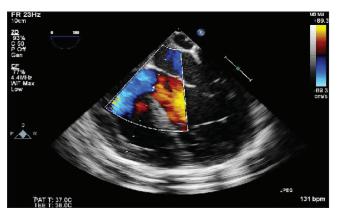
Midesophageal four chamber view with color flow Doppler showing sub aortic ventricular septal defect with a left to right shunt
